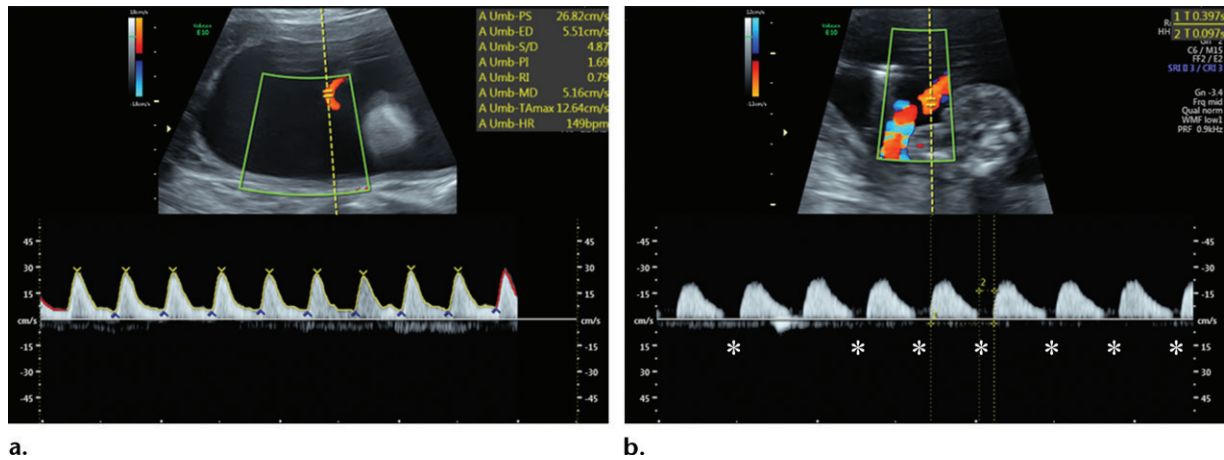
Duplex US images of the umbilical artery in a second-trimester fetus. (a) Color Doppler US image at the free loop of the umbilical cord shows a normal spectral waveform with continuous flow throughout the cardiac cycle. (b) Color Doppler US image just distal to the abdominal insertion of the umbilical cord shows an abnormal spectral waveform with absent end-diastolic flow (*).
